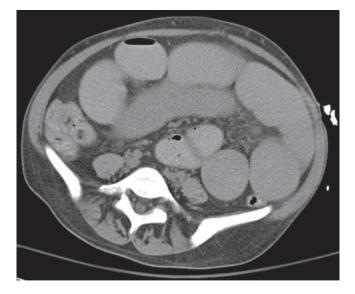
Distal Intestinal Obstruction Syndrome of Cystic Fibrosis. Computed tomographic image shows dilated loops of fluid-filled small bowel throughout the abdomen and pelvis with fecalization of bowel contents and gradual tapering of small-bowel caliber in the distal ileum.
